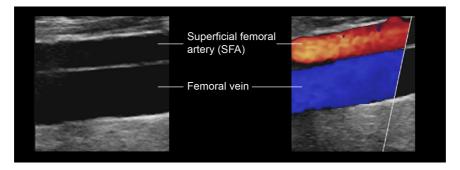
The superficial femoral artery (SFA) is located just above the femoral vein on transverse duplex ultrasound.
